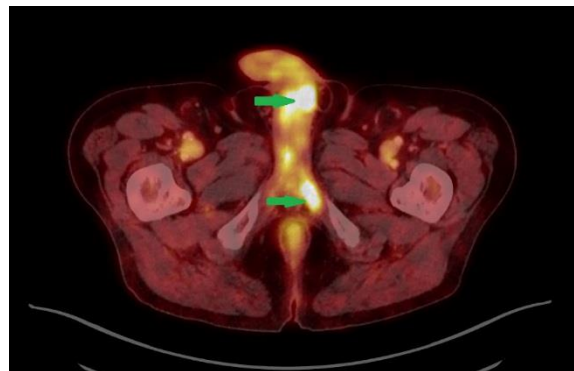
Primary ⁶⁴Cu-PSMA PET/CT showing enhanced metabolic activity in the the soft tissue surrounding the penis base as well as in the left crus of the penis (green arrows), PSA 31 µg/L
